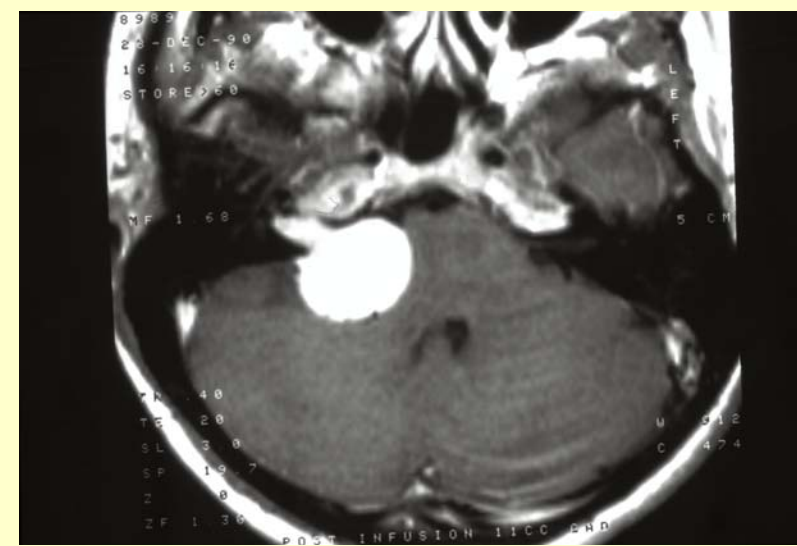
T1 MRI Acoustic neuroma.
